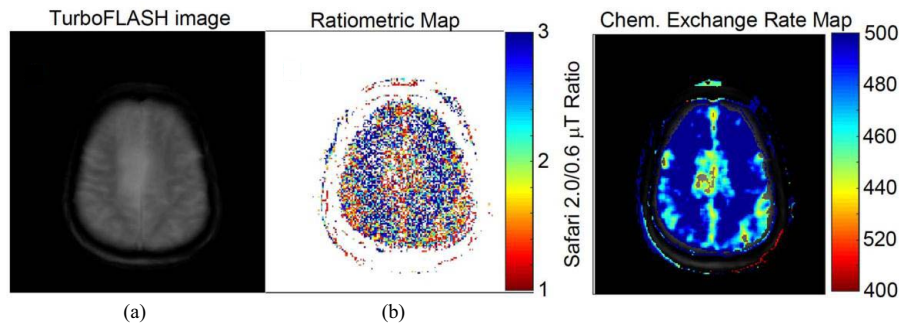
CEST MRI may differentiate tumor recurrence from radiation-induced inflammation. (a) Standard TurboFLASH MR image shows a large region of inflammation in a patient with glioblastoma treated with radiation therapy. Tumor recurrence cannot be identified within this region of inflammation. (b) Patient was also analyzed with SAFARI MRI, a variation of CEST MRI performed at 2 and 6 uT saturation powers. (c) Chemical exchange rate map derived from multipower SAFARI MRI showed regions with low chemical exchange rates between endogenous proteins and water. Because chemical exchange between proteins and water is base catalyzed, the low chemical exchange rate was attributed to low pH, which was likely caused by acidosis from dysregulated metabolism in a recurring solid tumor (Image courtesy of Mark Pagel).
